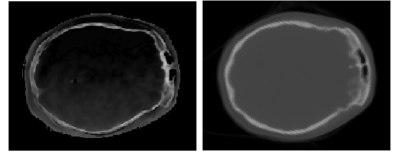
Transaxial slice of the corrected R_2 -map (left) and CT (right) of a clinical brain data set.
